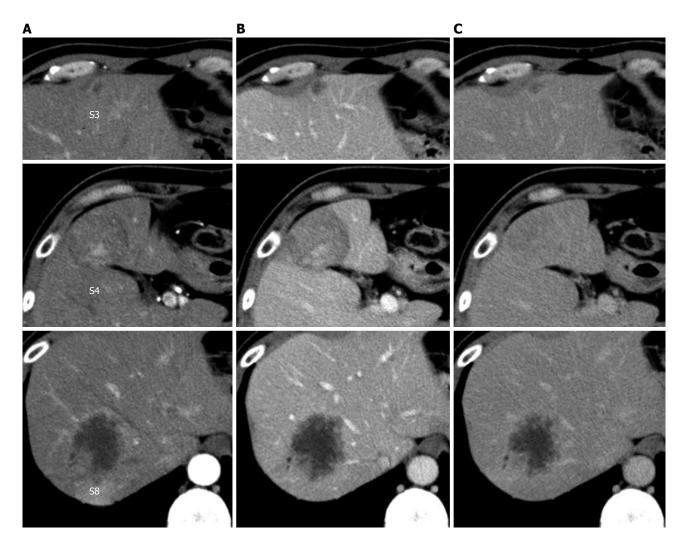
Dynamic computed tomography of the liver. A: Arterial phase; B: Portal phase; C: Venous phase. A hypo- or iso-dense tumor with heterogeneous enhancement in segment 4, a hypodense tumor with peripheral enhancement in segment 8, and a small hypodense tumor in segment 3.
